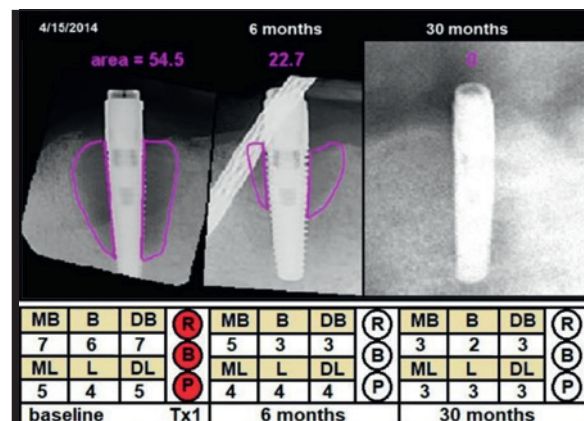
Example of a successful treatment (Case 1), showing changes in radiographic defect (mm²), probing depth (PD; mm) and clinical signs from baseline to 30 months later. Violet = cross-sectional area; MB = mesiobuccal PD; B = buccal PD; DB = distobuccal PD; ML = mesiolingual PD; L = lingual PD; DL = distolingual PD; R = redness; B = bleeding; P = suppuration; Tx1 = first treatment.
